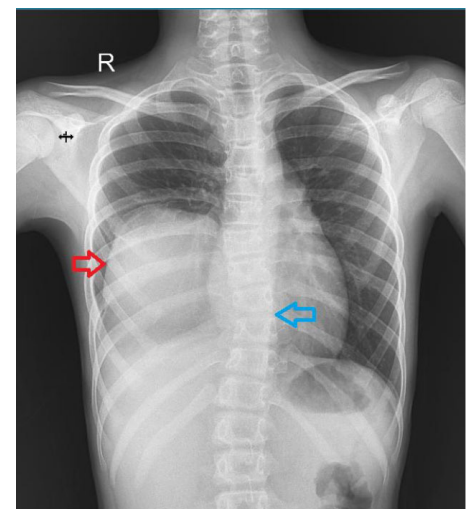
Pre-operative chest x-ray showed an opaque shadow with a sharp border in the middle to lower right lung field with suspicion of abscess or mass (red arrow), accompanied by scoliosis thoracalis vertebrae (blue arrow).
